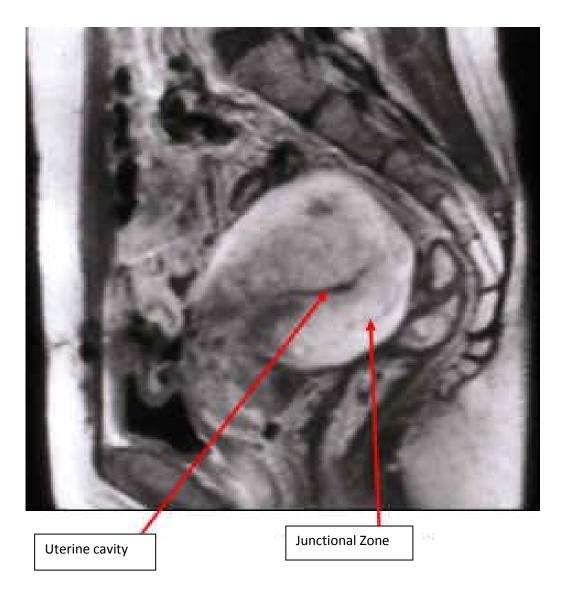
Thickened junctional zone on T1-weighted imaging
